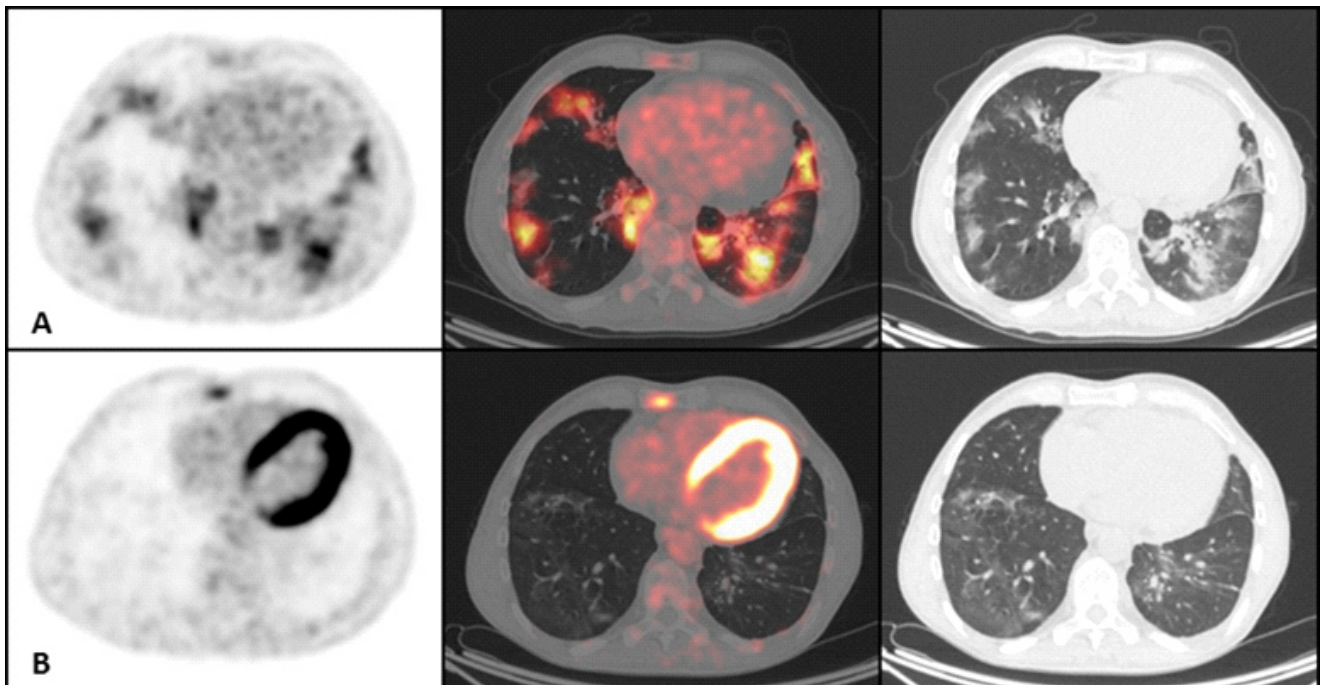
Axial PET, fused PET/CT and CT images of lower lung lobes, showing (horizontally) A: High ¹⁸F-FDG uptake in ground-glass opacities in both lungs, consistent with an active SARS-CoV-2 infection and B: Near complete resolution of the lung lesions two months later, but a progression of bone metastatic lesions in a patient with renal cell cancer.
